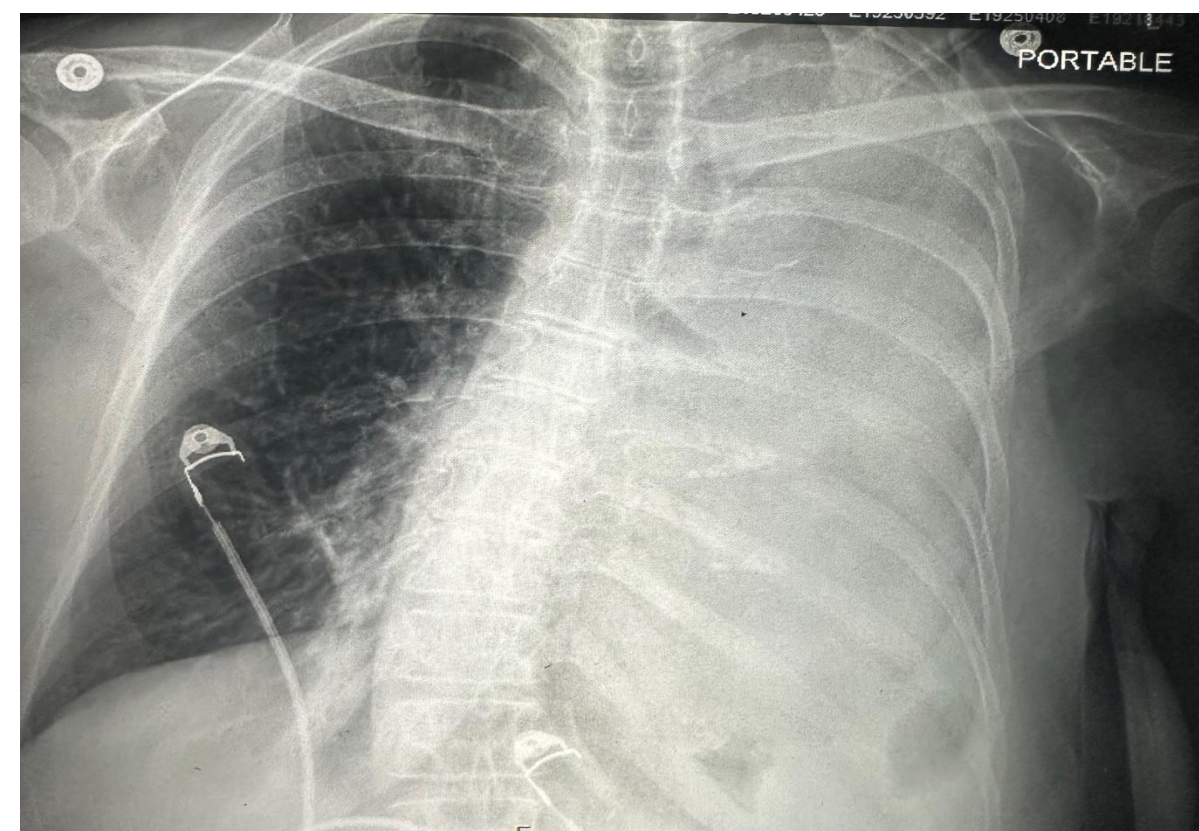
Chest x-ray showing complete opacification of the left lung with mild mediastinal deviation to the Left.
